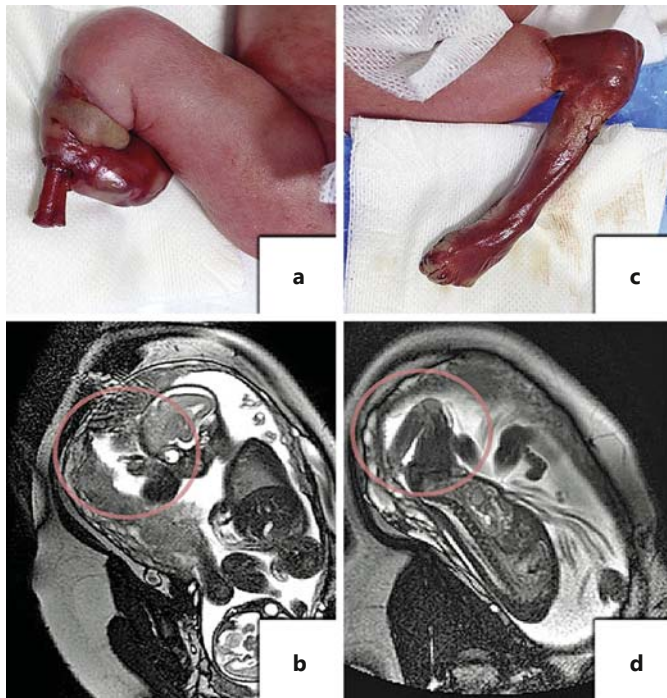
Multiple limb ischemia with different macroscopic findings between the right (a, b) and left (c, d) lower extremity, documented by fetal MRI (circles) and immediately after birth.
